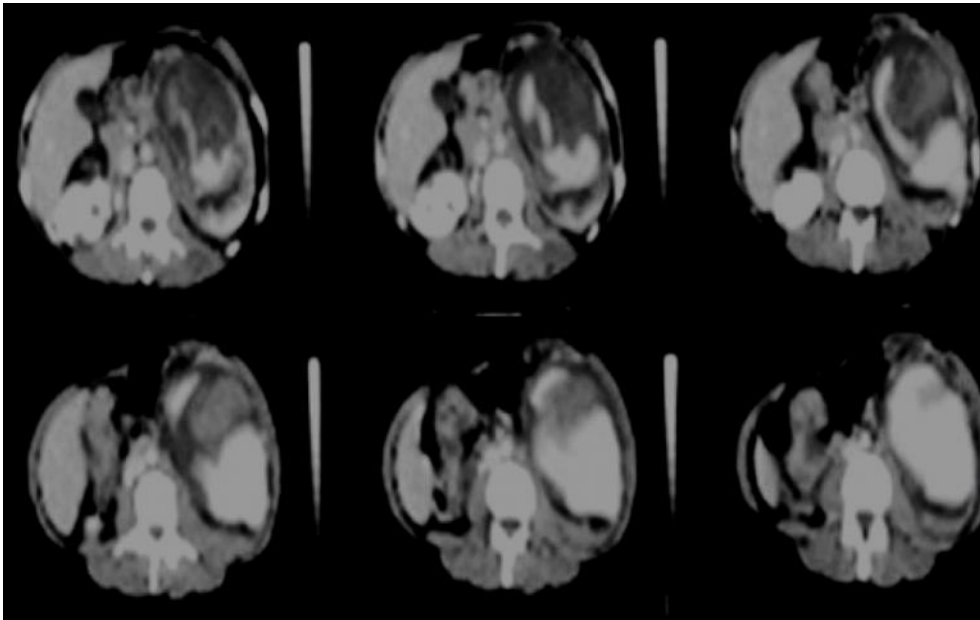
Abdominal computed tomography images obtained at an outside hospital showing giant pseudo-aneurysm originating from the left kidney. Multiple hypodense lesions are also seen suggestive of renal angiomyolipomas.
